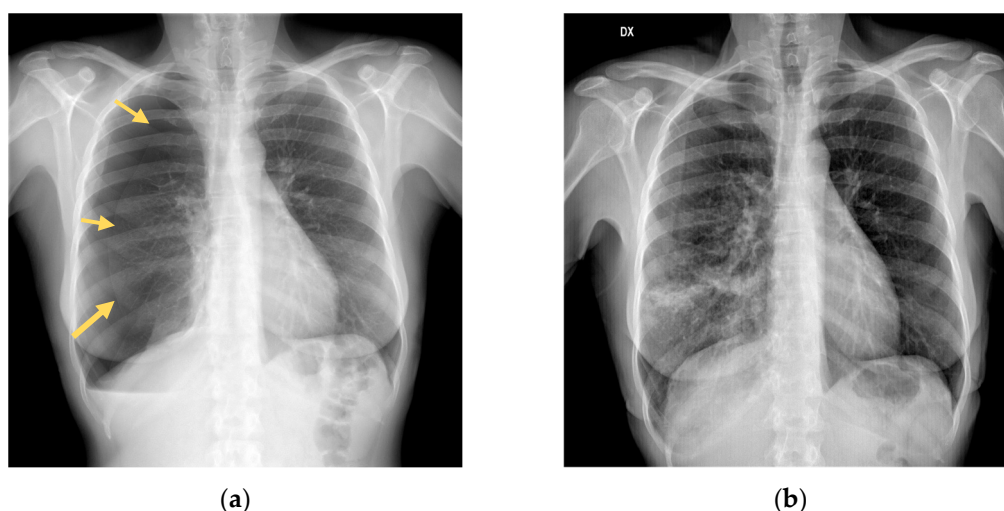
a) Initial chest X-ray shows a right pneumothorax of 55 mm; (b) Chest X ray evaluation, after needle aspiration, shows expansion of lung parenchyma with reduction of pneumothorax.
